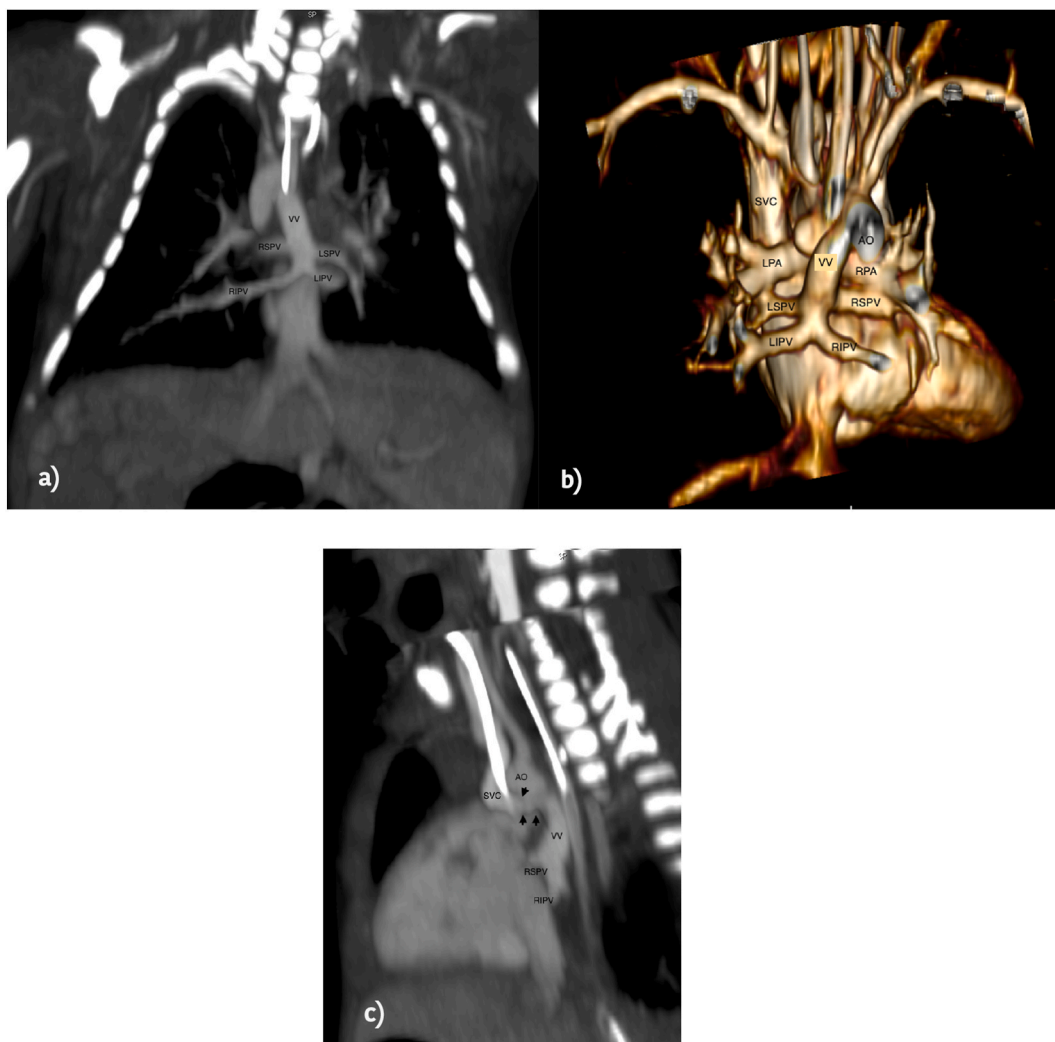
Contrast-enhanced computed tomography para-coronal (a), para-sagittal (c) MPR and VR (b) reconstruction of type I TAPVC draining in SVC via a vertical vein in a complex CHD with dextrocardia in situs inversus. SVC = Superior vena cava; AO = Aorta; VV = Vertical vein; RSPV = Right superior pulmonary vein; RIPV = Right inferior pulmonary vein; LSPV = Left superior pulmonary vein; LIPV = Left inferior pulmonary vein.
